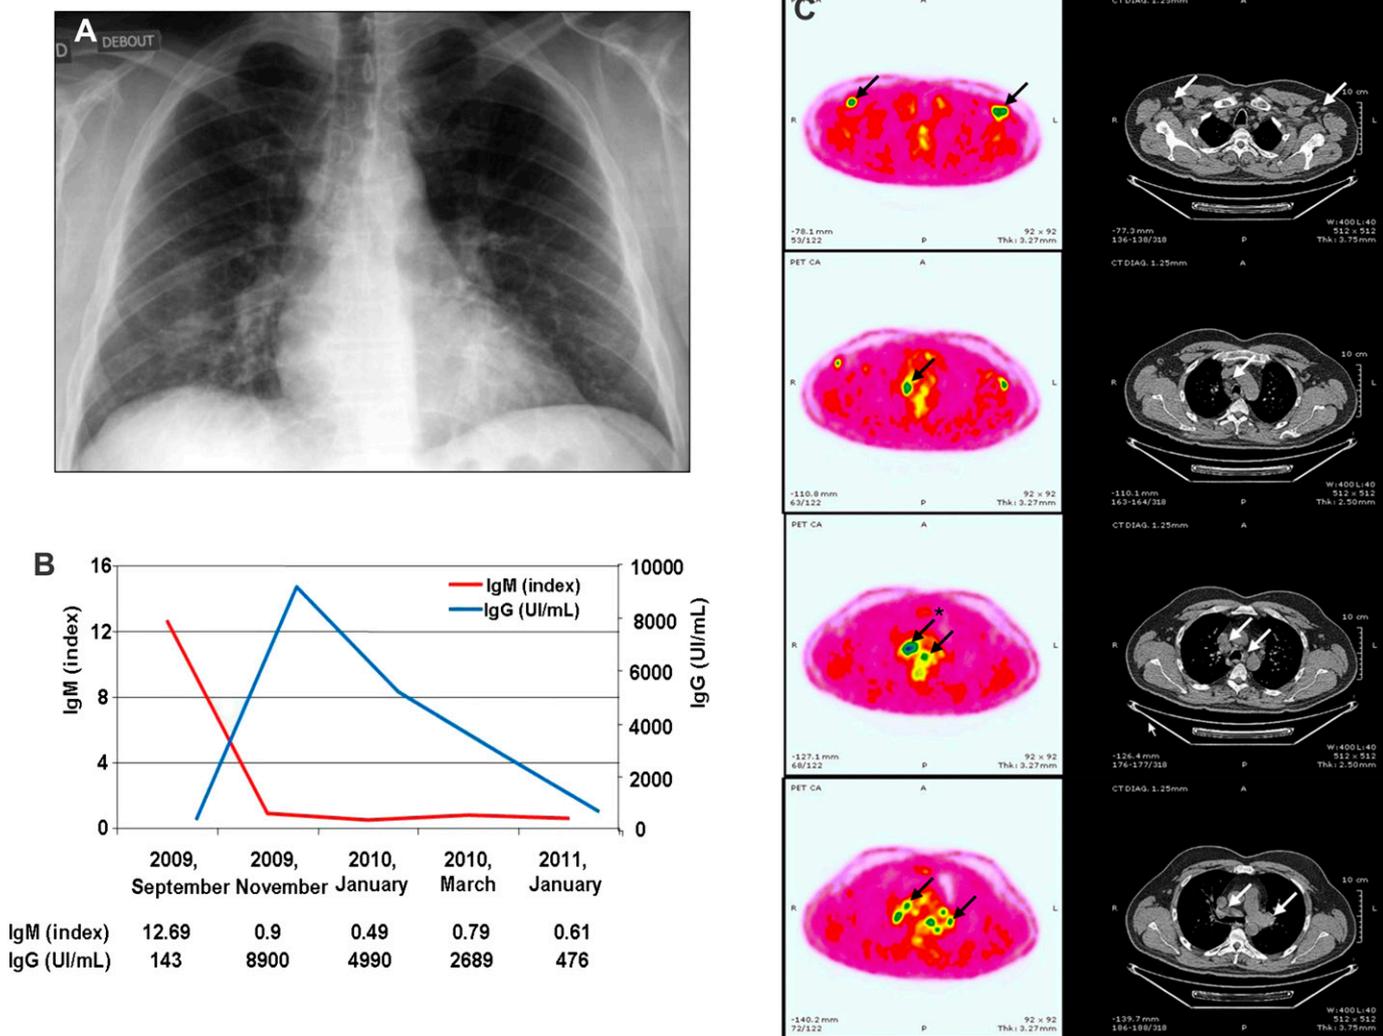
(A) Chest radiograph revealed subtle diffuse interstitial infiltrates. (B) The *Toxoplasma gondii* serological status evolution suggested a recent primary infection: a rapid increase IgG was associated with decrease of specific IgM (IgG titers ≥ 3 IU/ml and IgM index ≥ 0.6 are considered positive; AxSYM system, Abbott Laboratories, Lake Forest, IL). (C) The 18-fluorodeoxyglucose PET/CT scan showed uptake in the peripheral and mediastinal lymphadenopathy (arrows). The standardized uptake values were: 4 g/ml in axillary and mediastinal adenopathy, except in the adenopathy marked with an asterisk (6.3 g/ml).
